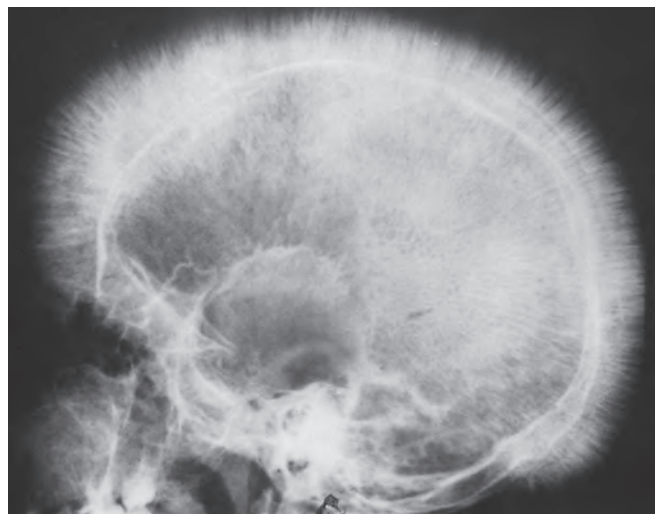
β*-Thalassemia major. X-ray film of the skull showing new bone formation on the outer table, producing perpendicular radiations resembling a crewcut. (Courtesy Dr. Jack Reynolds, Department of Radiology, University of Texas Southwestern Medical School, Dallas, Tex.)
